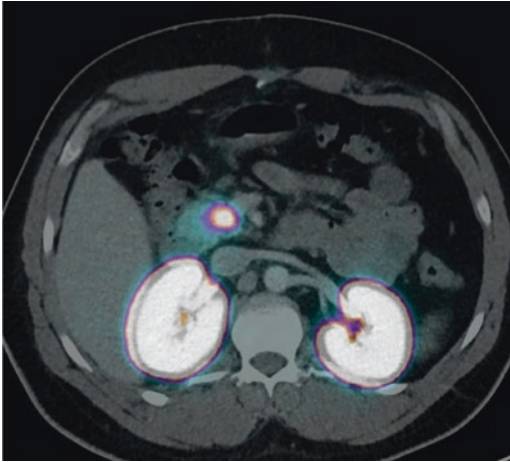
A representative imaging picture of the ^{68}Ga -DOTA-Exendin-4 PET-CT showing the intensive isotope uptake of a small tumor in the lower part of the pancreas head ventral to the inferior vena cava
